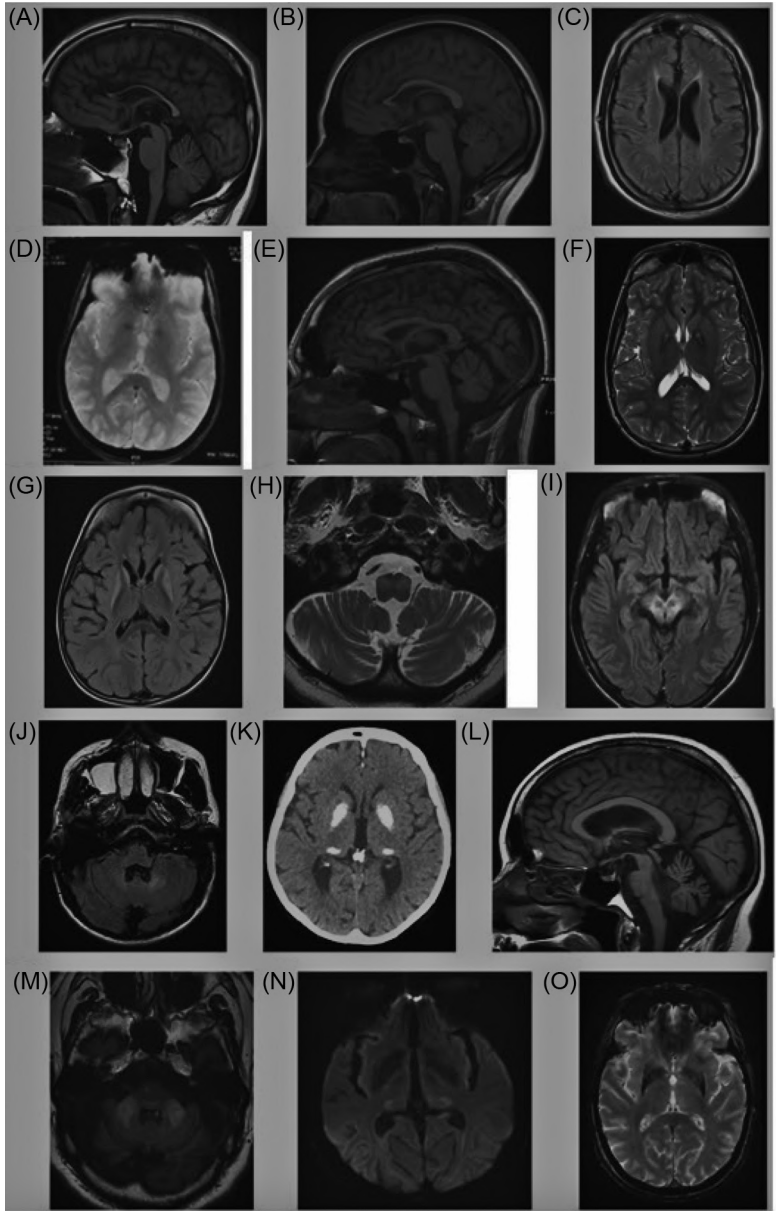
MRI abnormalities in different parkinsonian-pyramidal syndromes.¹⁵¹
